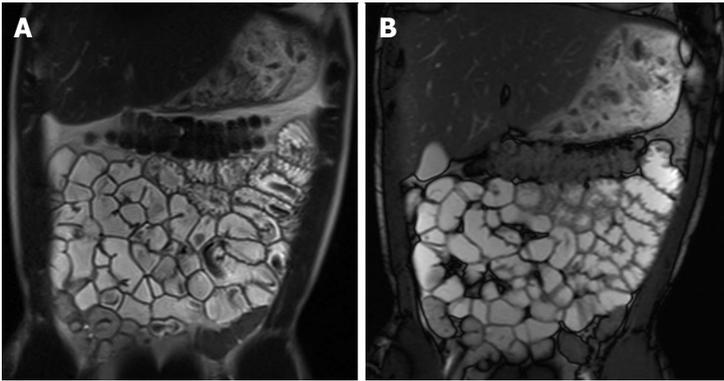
Coronal T2-weighted single shot fast spin echo and coronal balanced steady state free precession images. Good bowel distension is achieved with the administration of peroral fluid (A and B). Balanced steady state free precession sequence (B) is robust to flow voids; in addition to its ability to demonstrate fine anatomical details including bowel thickness, mesenteric vessels and lymph nodes; even without the use of spasmolytic agents.
